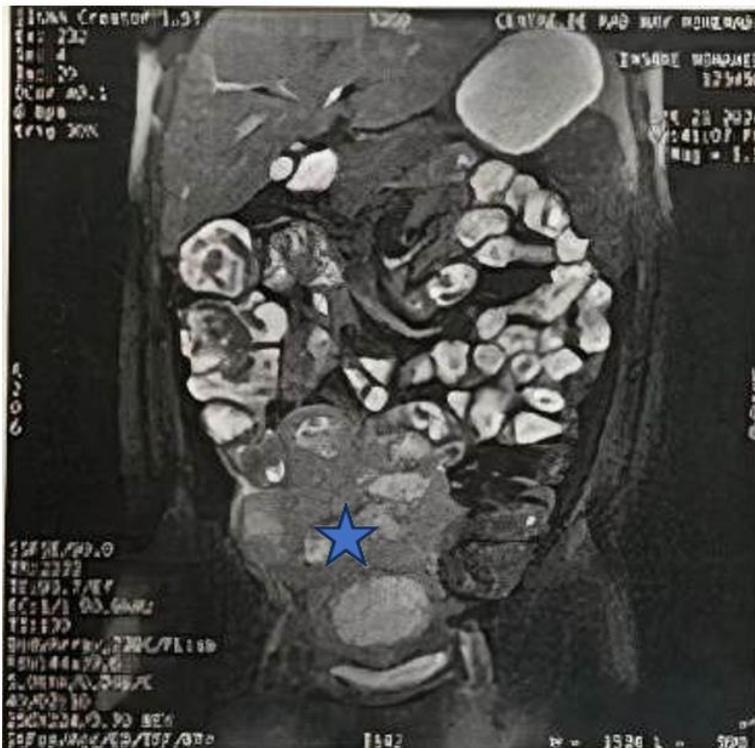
Frontal entero-MRI showing a solid-necrotic process of 14 x 13 x 8 cm starting at the level of the bladder dome and rising upwards towards the hypogastrium and the FID seeming to communicate with the digestive loops.
